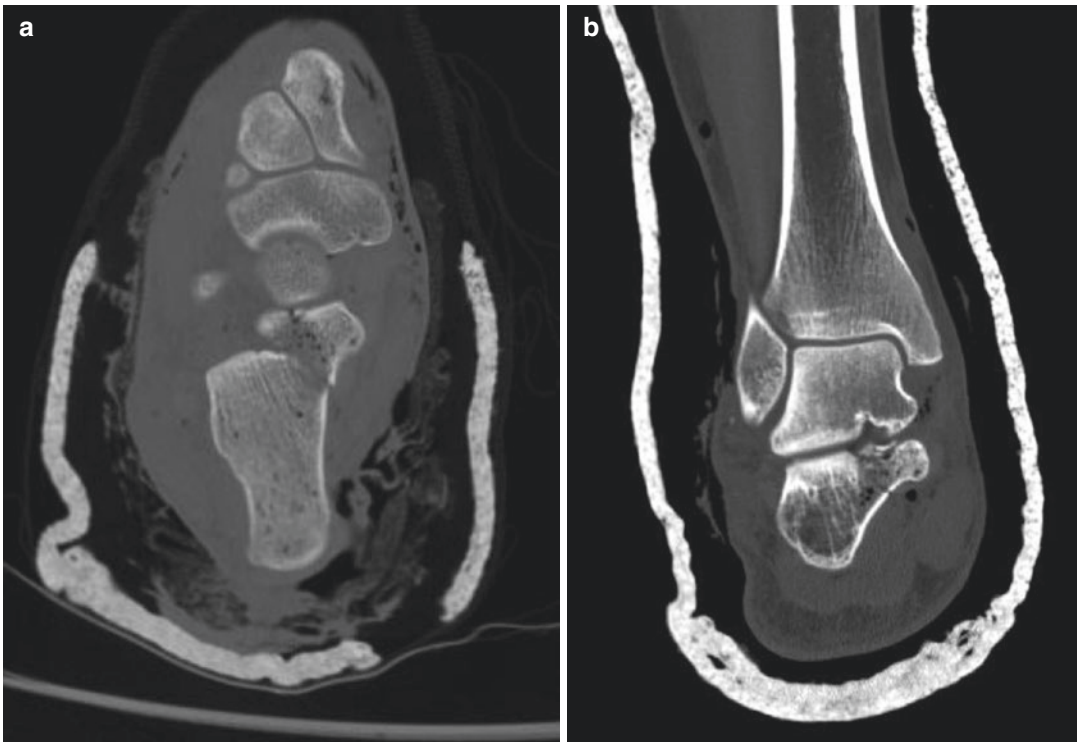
(a, b) Select CT injury images for Case 2. “Select axial cut (a) shows a fracture of the sustentaculum tali, and coronal (b) demonstrates the sagittal nature of the fracture line”
